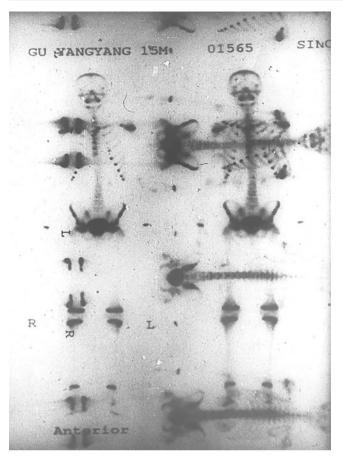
Increased signal intensity in the proximal aspect of left humerus by SPECT
